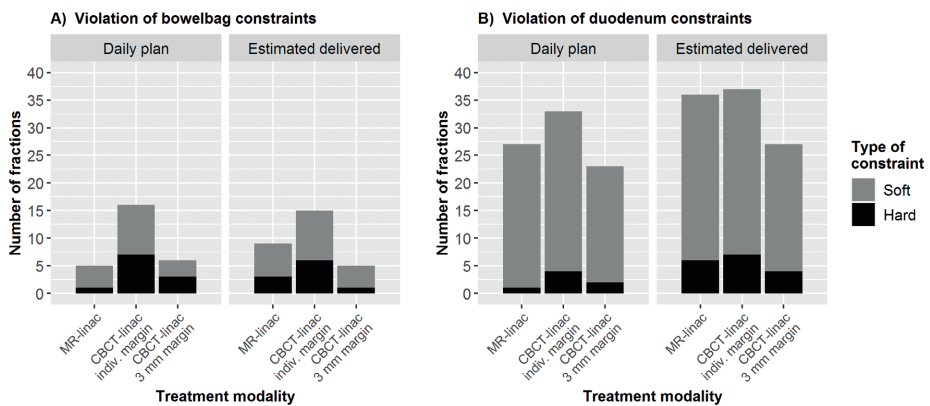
Violation of planning constraints using MR-linac and CBCT-linac SBRT for lymph node oligometastases. Number of individual treatment fractions for which soft and hard constraints were violated are shown for bowelbag (A) and duodenum (B). Results were calculated for MR-linac (3 mm PTV margin), CBCT-linac with the individualized PTV margin and CBCT-linac with 3 mm PTV margin. Constraint violations are shown at two time points: anatomy at the start of the treatment fraction (daily plan) and estimated anatomy at the moment of radiation delivery (estimated delivered, average of pre/PV scans for CBCT-linac and average of PV/post scans for MR-linac). Applicable planning constraints are shown in Supplementary Material: Table S1.
